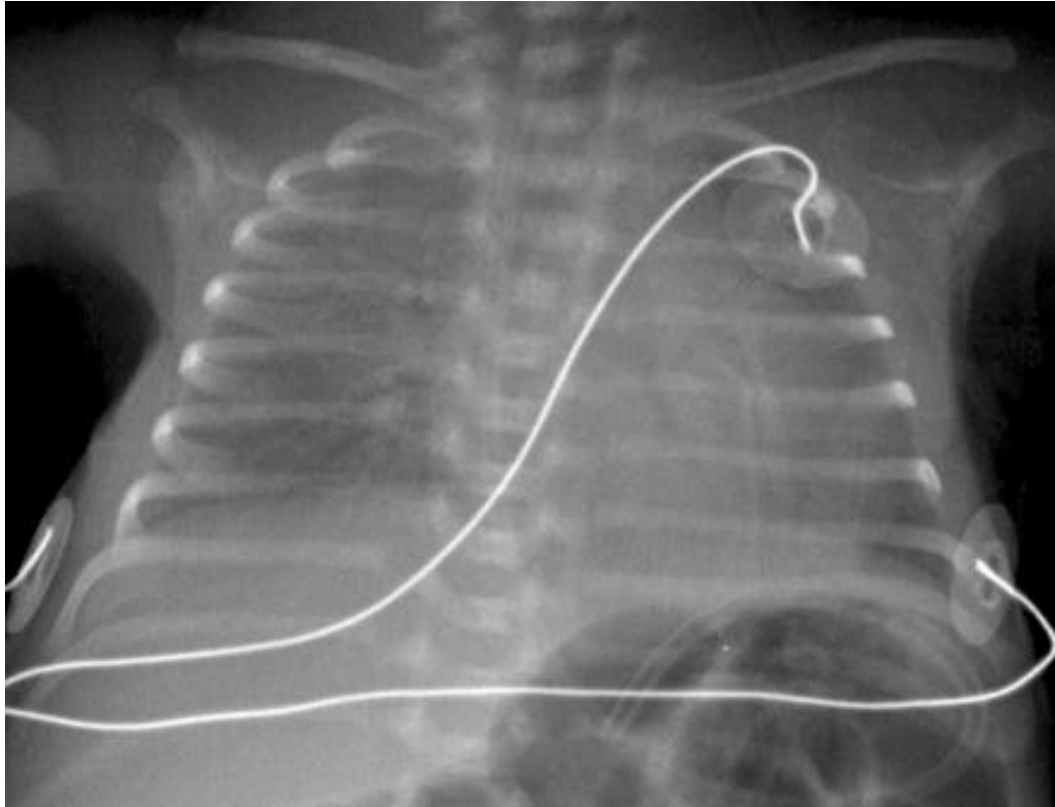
Standard-dose X-ray in which evaluation of the mediastinal border is not possible due to patient rotation error
